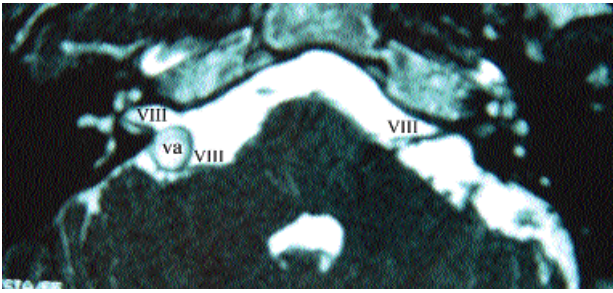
MRI assessment with gadolinium T2 CISS sequence show the presence of the right vertebral artery (va) distorting the acousticofacial nerve bundle (VIII) at its cisternal course. (MRI, magnetic resonance imaging; CISS, constructive interference in study state.)
